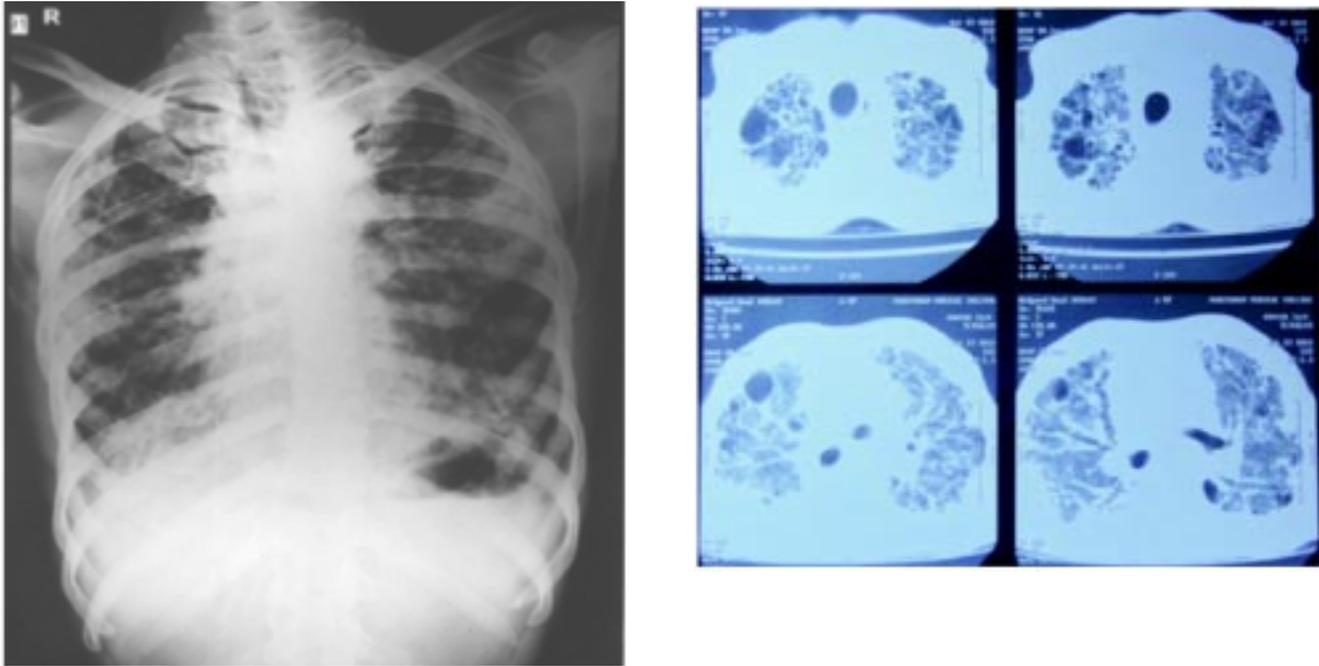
(A) Chest X ray , (B) HRCT
